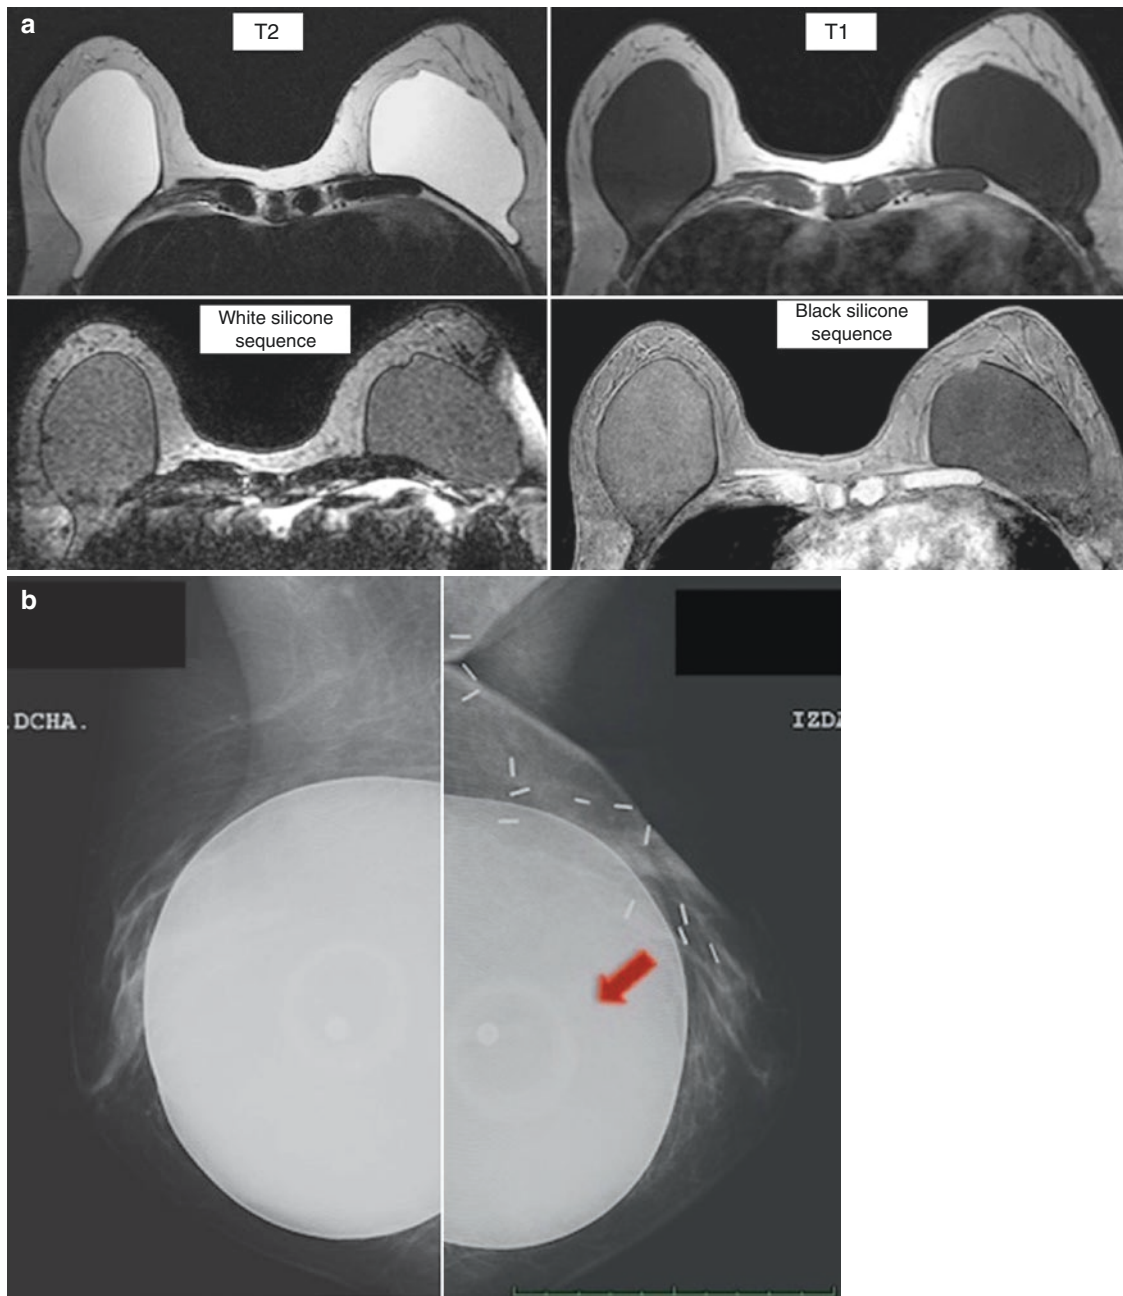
Patient with breast-conserving surgery in UOQ of the left breast and reconstruction with saline solution implants. (a) MRI was performed without the presence of a radiologist, and the type of implants was unknown, so white silicone and black silicone sequences were made. The saline solution implants show identical signal intensity of the liquid which was hypointense on T1 and hyperintense on T2 (higher hyperintensity than silicone). On black and white silicone
